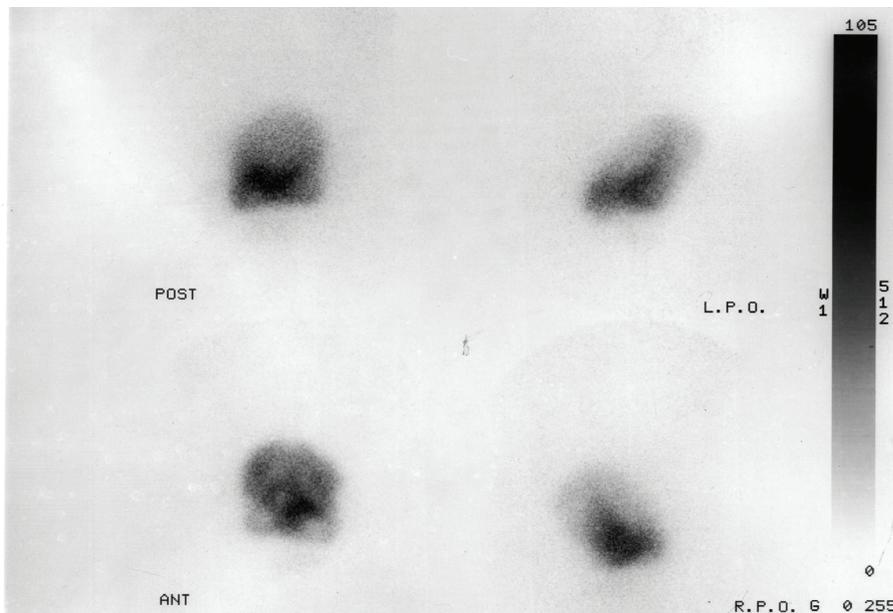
Tc-99m DMSA scintigraphy shows an irregular Tc-99m uptake in a single mass of kidney located in pelvis. In some areas of the kidney less activity uptake is seen, which indicates loss of parenchyme function.
